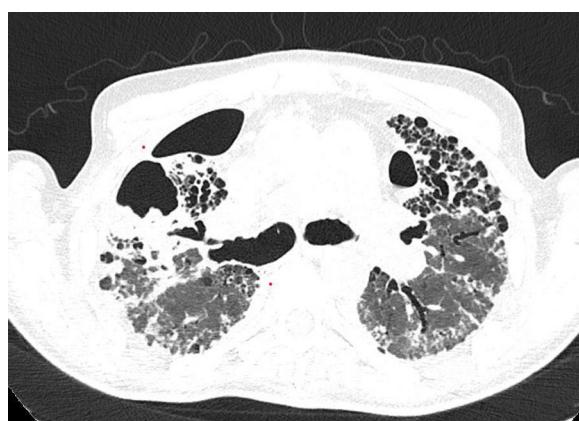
Chest CT scan of the patient before admission.
